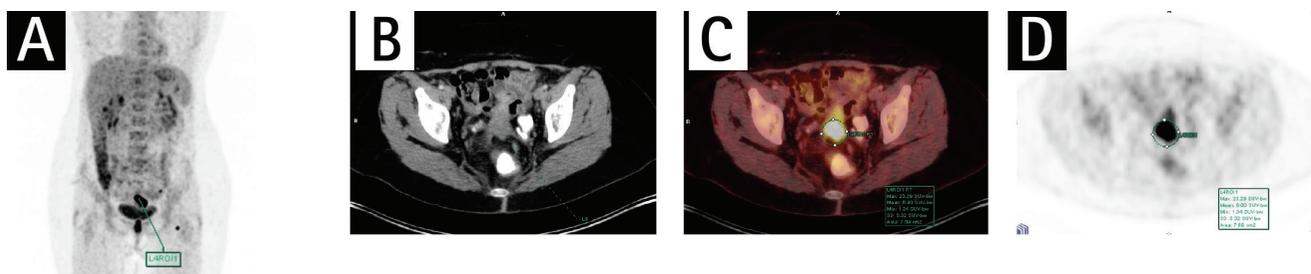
Maximum standardized uptake value of the primary tumor was measured 23,29. Non-endometrioid type (serous) endometrial carcinoma (grade 3, International Federation of Gynecology and Obstetrics stage 3C). A) Maximum intensity projection image. B) Transaxial computed tomography image. C) Transaxial positron emission tomography+computed tomography fusion image. D) Transaxial positron emission tomography image of the primary tumor
